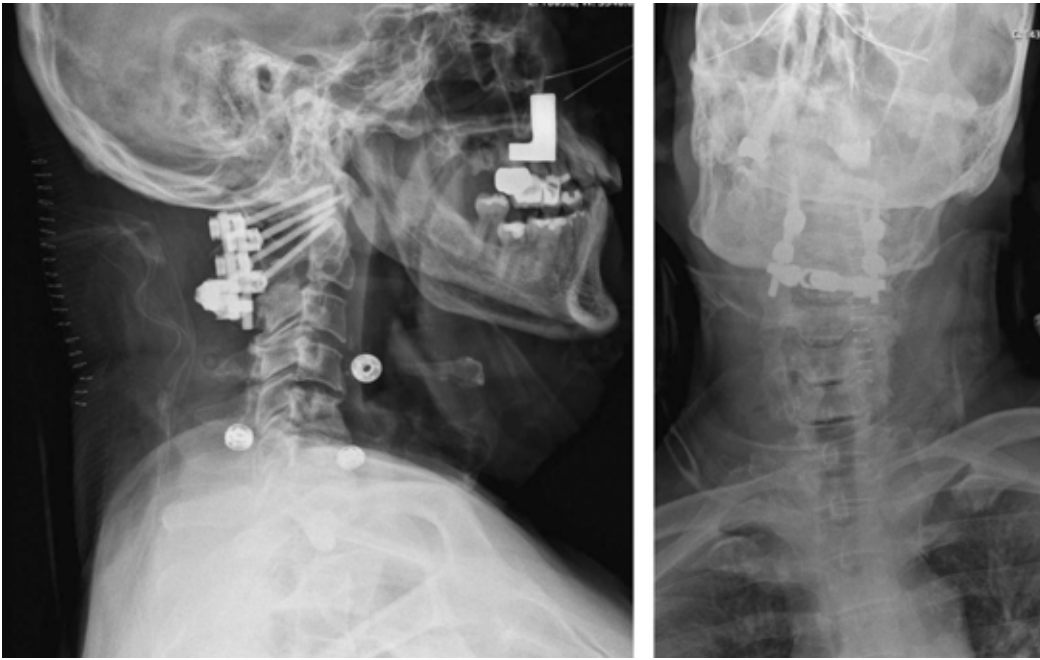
Lateral and AP radiographs showing the final construct, C1-C2 fusion with a cross-link at the caudal aspect of the construct.
